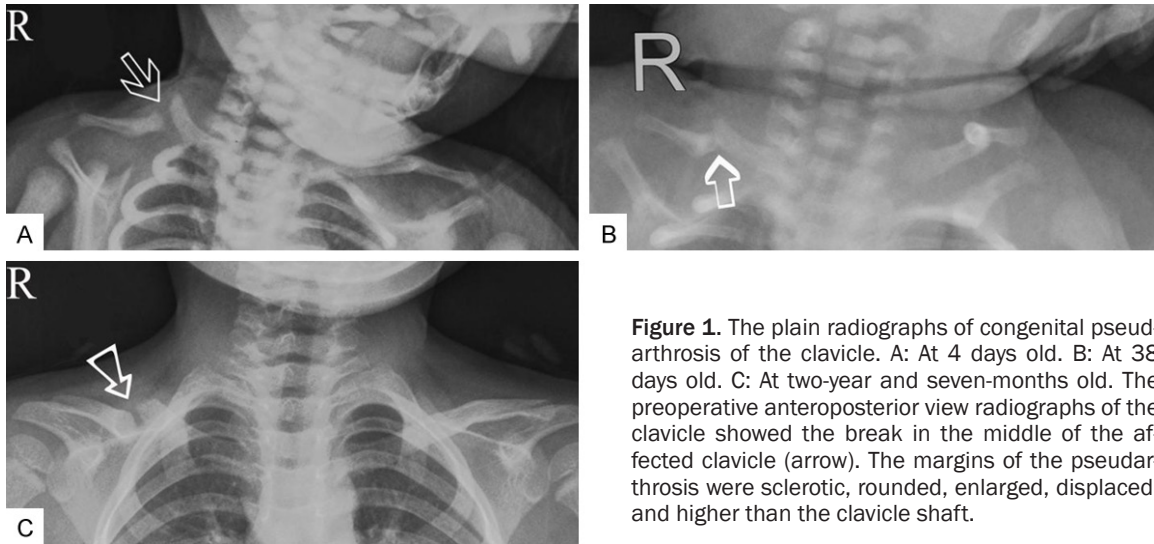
The plain radiographs of congenital pseudarthrosis of the clavicle. A: At 4 days old. B: At 38 days old. C: At two-year and seven-months old. The preoperative anteroposterior view radiographs of the clavicle showed the break in the middle of the affected clavicle (arrow). The margins of the pseudarthrosis were sclerotic, rounded, enlarged, displaced, and higher than the clavicle shaft.
